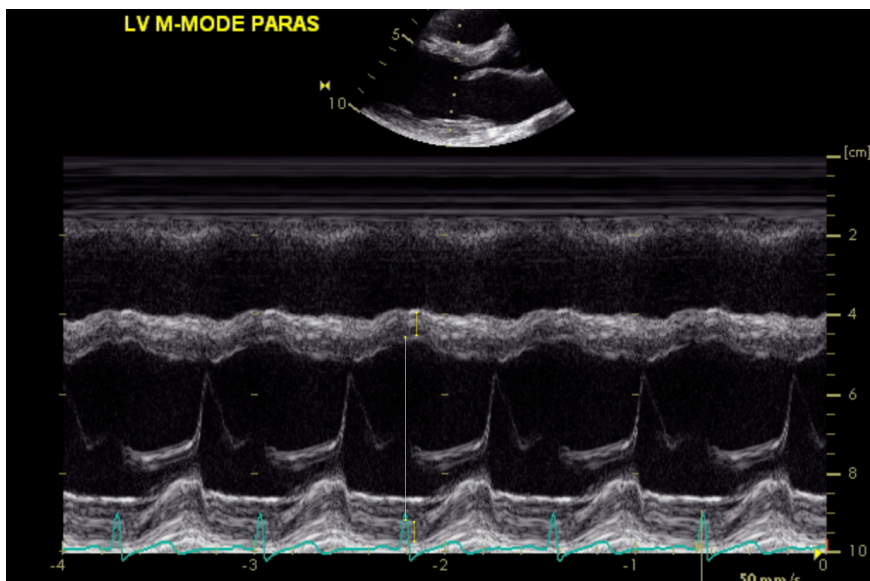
M-mode ultrasound image obtained during measurement of cardiac LVM.
